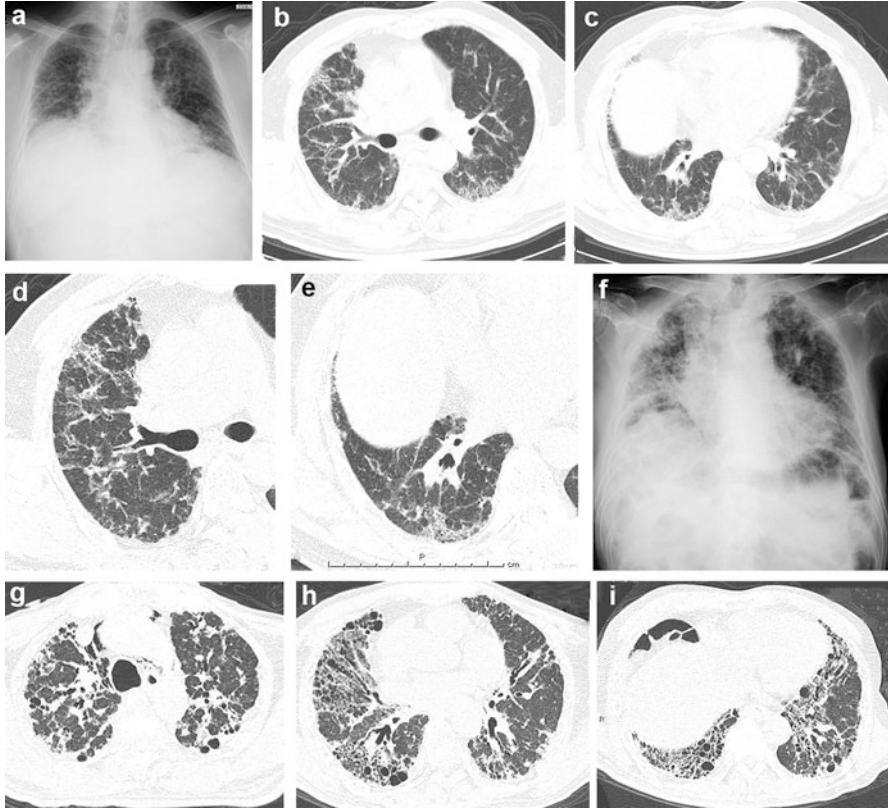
Chronic fibrosing interstitial pneumonia of unknown cause with definite usual interstitial pneumonia (UIP) pattern at pathology and atypical (inconsistent with) UIP pattern at high-resolution computed tomography (HRCT). (a–g) Images at surgical lung biopsy; (f–i) images were obtained 4 years later. (a) Chest x-ray shows volume loss in bilateral lungs with reticular opacity. (b) HRCT at the middle lung shows ground-glass opacity (GGO) and reticular opacity in the peribronchovascular regions in bilateral lungs. (c) GGO and reticular opacity predominant in basal regions. Abnormal opacity is identified in both subpleural and peribronchovascular regions. (d) HRCT at the middle lung shows peribronchovascular abnormal opacity that represents a pattern inconsistent with UIP. (e) HRCT at the level of the lung base shows abnormal opacity in both the peribronchovascular and subpleural regions. (f) Chest x-ray after 4 years shows progression of abnormal opacity and loss of volume in bilateral lungs. (g) HRCT at the level of the pulmonary apex shows peribronchovascular and subpleural foci consolidation with traction bronchiectasis. (h) HRCT at the level of the middle lung shows peribronchovascular-predominant reticular opacity with traction bronchiectasis that suggests a pattern of fibrotic nonspecific interstitial pneumonia (fNSIP). (i) In the lung base, HRCT shows peribronchovascular-predominant reticular opacity that includes traction bronchiectasis and cysts
